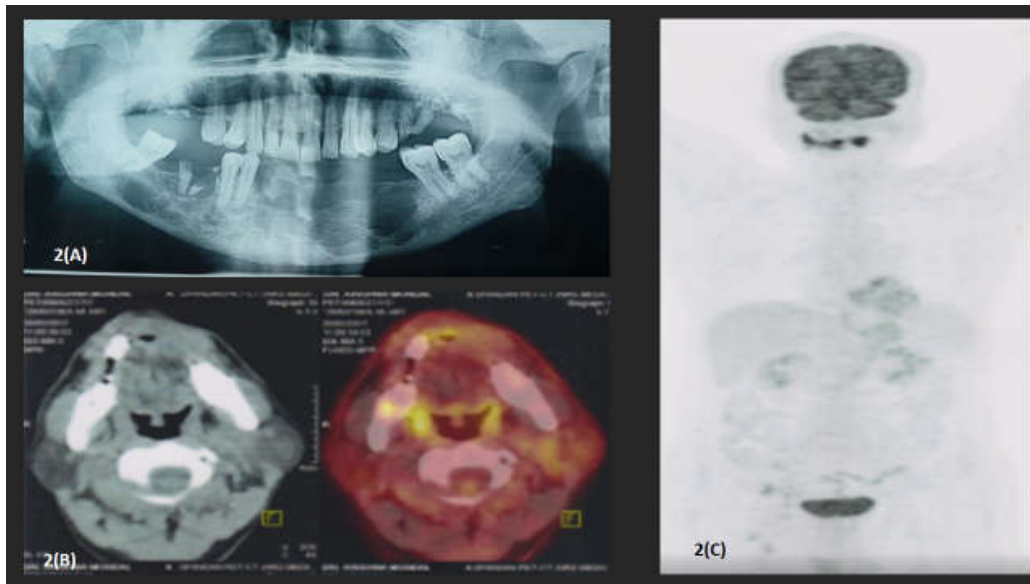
(A) Orthopantomogram showing multilocular, mixed radioluscent lesion involving the parasymphseal and left side of the body of the mandible.(B),(C) PET-CT scan of the whole body revealed osteolytic lesion of entire length of the mandible with multiple punched out lesions and soft tissue extensions into adjoining lower alveolus
